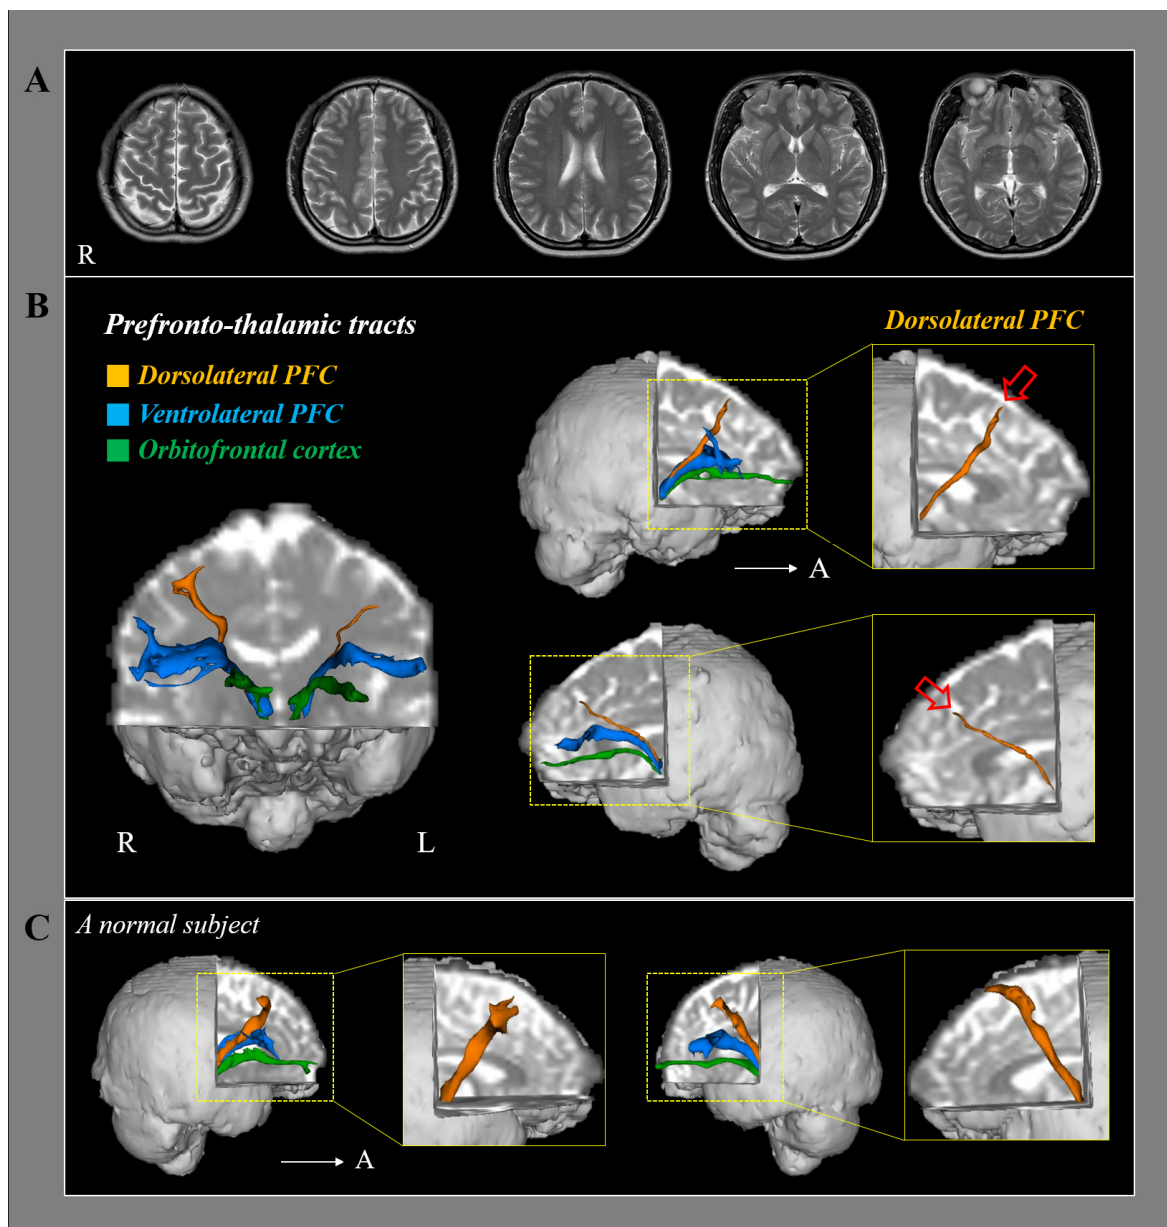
Results of diffusion tensor tractography (DTT) of the prefronto-thalamic tracts. (A) T2-weighted brain magnetic resonance images show no abnormality in a representative patient (35-year-old female). (B) Results of DTT of the prefronto-thalamic tracts, the dorsolateral prefrontal cortex (DLPFC) show narrowing (red arrow) on the both side compared with a normal subject. (C) DTT results of the prefronto-thalamic tracts in a representative normal subjects (33-year-old female).
